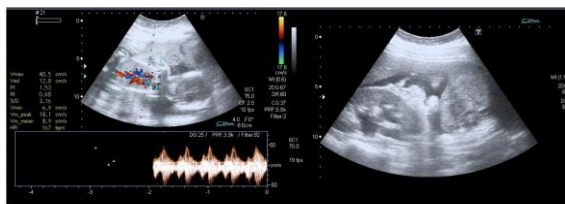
Ultrasound showing moderate free intraperitoneal fluid with low level echoes (hematoma) and fetal tachycardia
